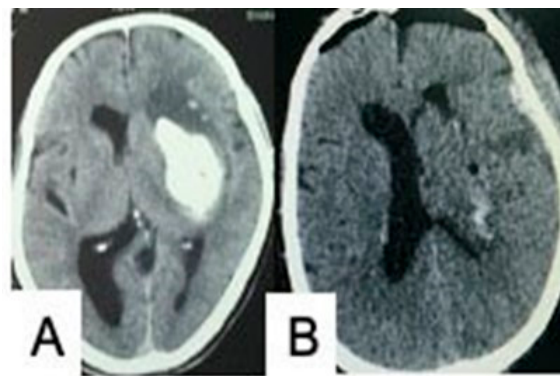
(A) CT scan showing a left-sided huge basal ganglionic hematoma. (B) Postoperative CT scan showing good removal of the hematoma, with no midline shift. Source: Figure by authors.
